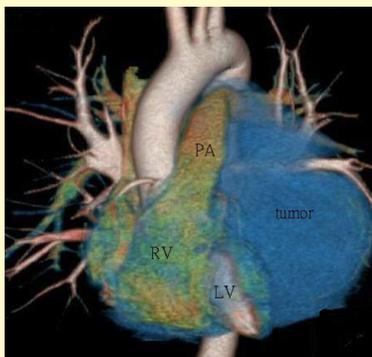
64-slice CT showed a huge heterogeneous mass of about 15 cm in length with hematoma formation and contrast enhancement in the posterior heart portion inside the pericardium, causing left-ventricle compression (LV: left ventricle).
